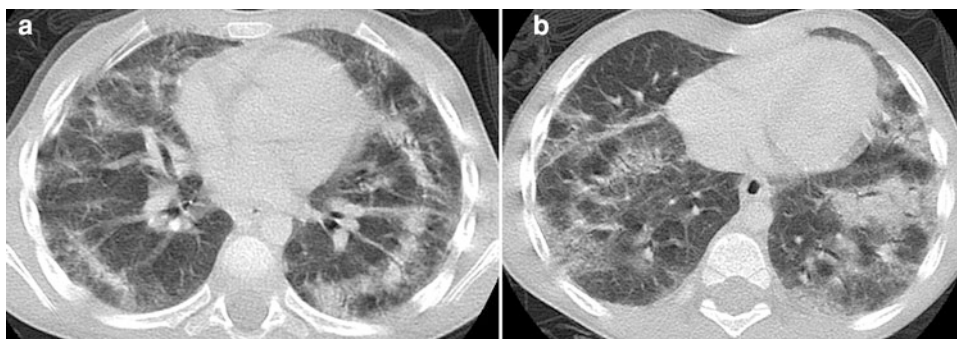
Acute interstitial pneumonia. An axial chest CT image (a) from a 2-year-old with fever and acute respiratory failure shows patchy bilateral ground-glass opacities and consolidation related to
